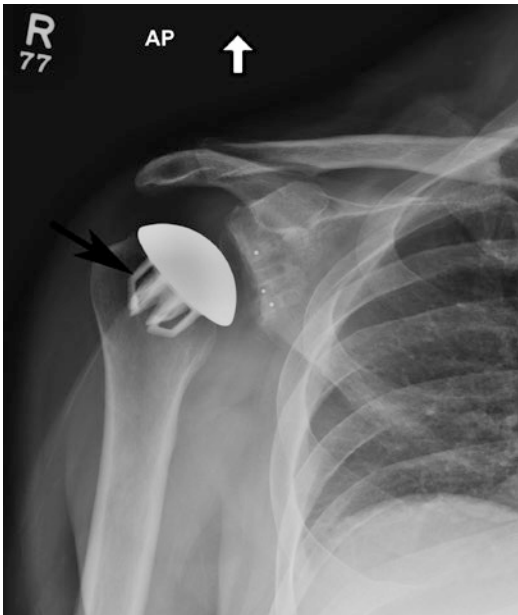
Anatomic total shoulder arthroplasty. AP radiograph of the right shoulder show a stemless humeral component (arrow) and polyethylene glenoid component
